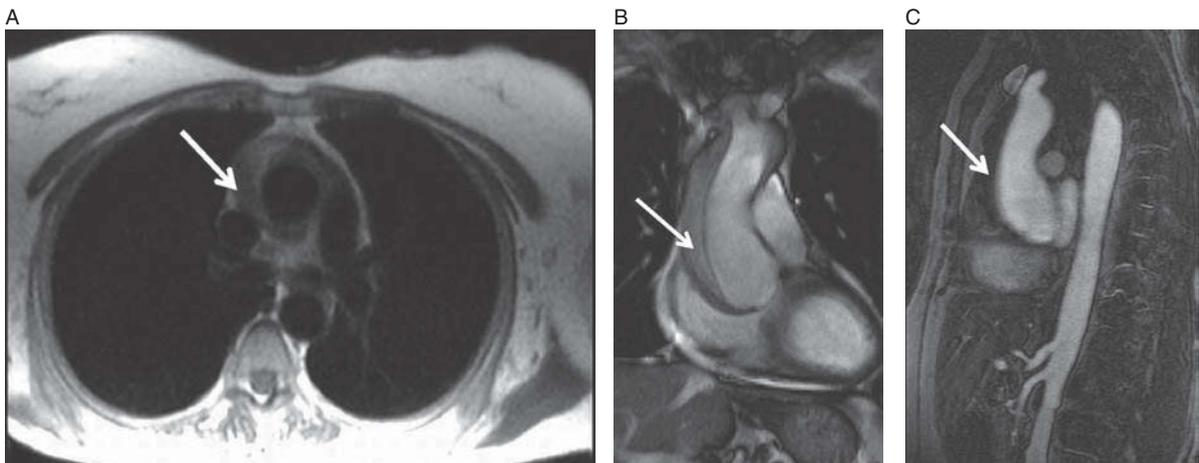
Intramural hematoma. Axial dark-blood image (A) and coronal bright-blood image (B) demonstrate bright blood products within the wall of the ascending aorta (arrow); however, no discrete flap is seen. T1-weighted, fat-saturated Post-contrast image (C) shows no enhancement of the wall confirming that there is no communication with the lumen.
